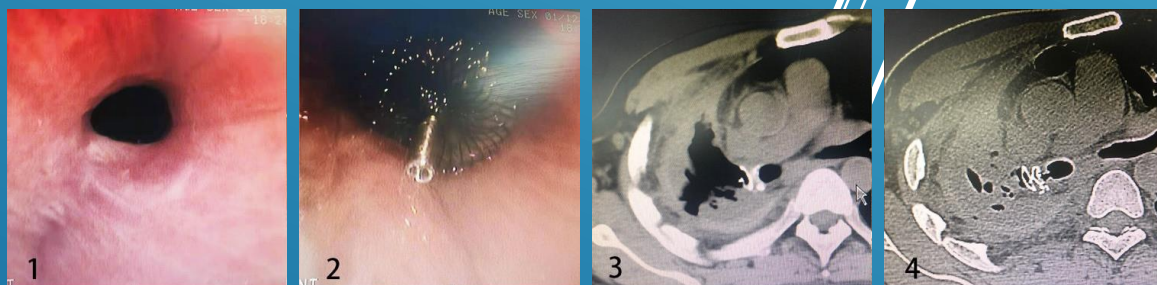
(4): Atrial septal defect occluder occlusion of the right main bronchus fistula. (1) Preoperative bronchoscope shown right main bronchus fistula; (2) Intraoperative placed with atrial septal defect occluder will completely block the fistula; (3) 1 week after chest CT images show good fistula closure; (4) 3 months after the chest CT mediastinal window images show occluder
